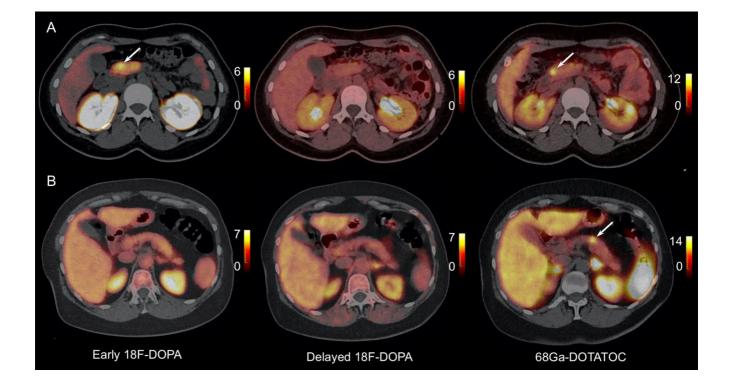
Discordant results of carbidopa-assisted ¹⁸F-DOPA and ⁶⁸Ga-DOTATOC PET/CT in two patients with pathologically proved insulinoma (arrows). (A) Early ¹⁸F-DOPA+/Delayed ¹⁸F-DOPA -/⁶⁸Ga-DOTATOC+. (B) Early ¹⁸F-DOPA-/Delayed ¹⁸F-DOPA-/⁶⁸Ga-DOTATOC+.
